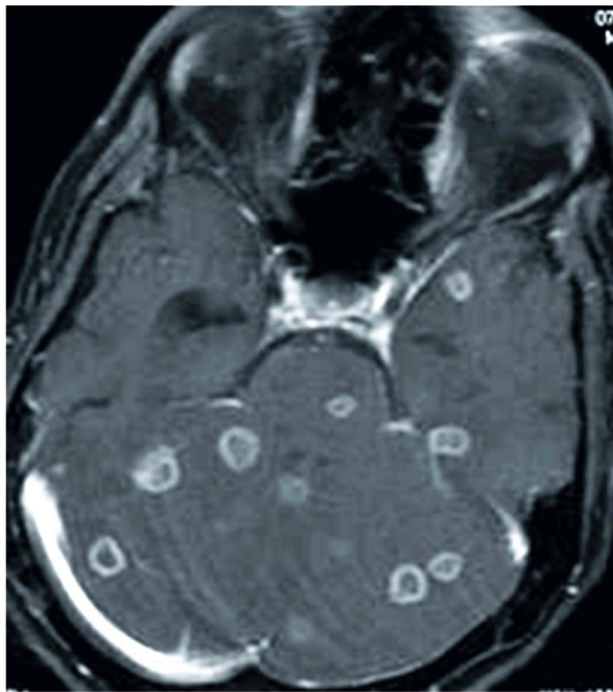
Contrast enhanced Sagittal MRI brain showing Multiple Tuberculoma predominantly in posterior fossa.
